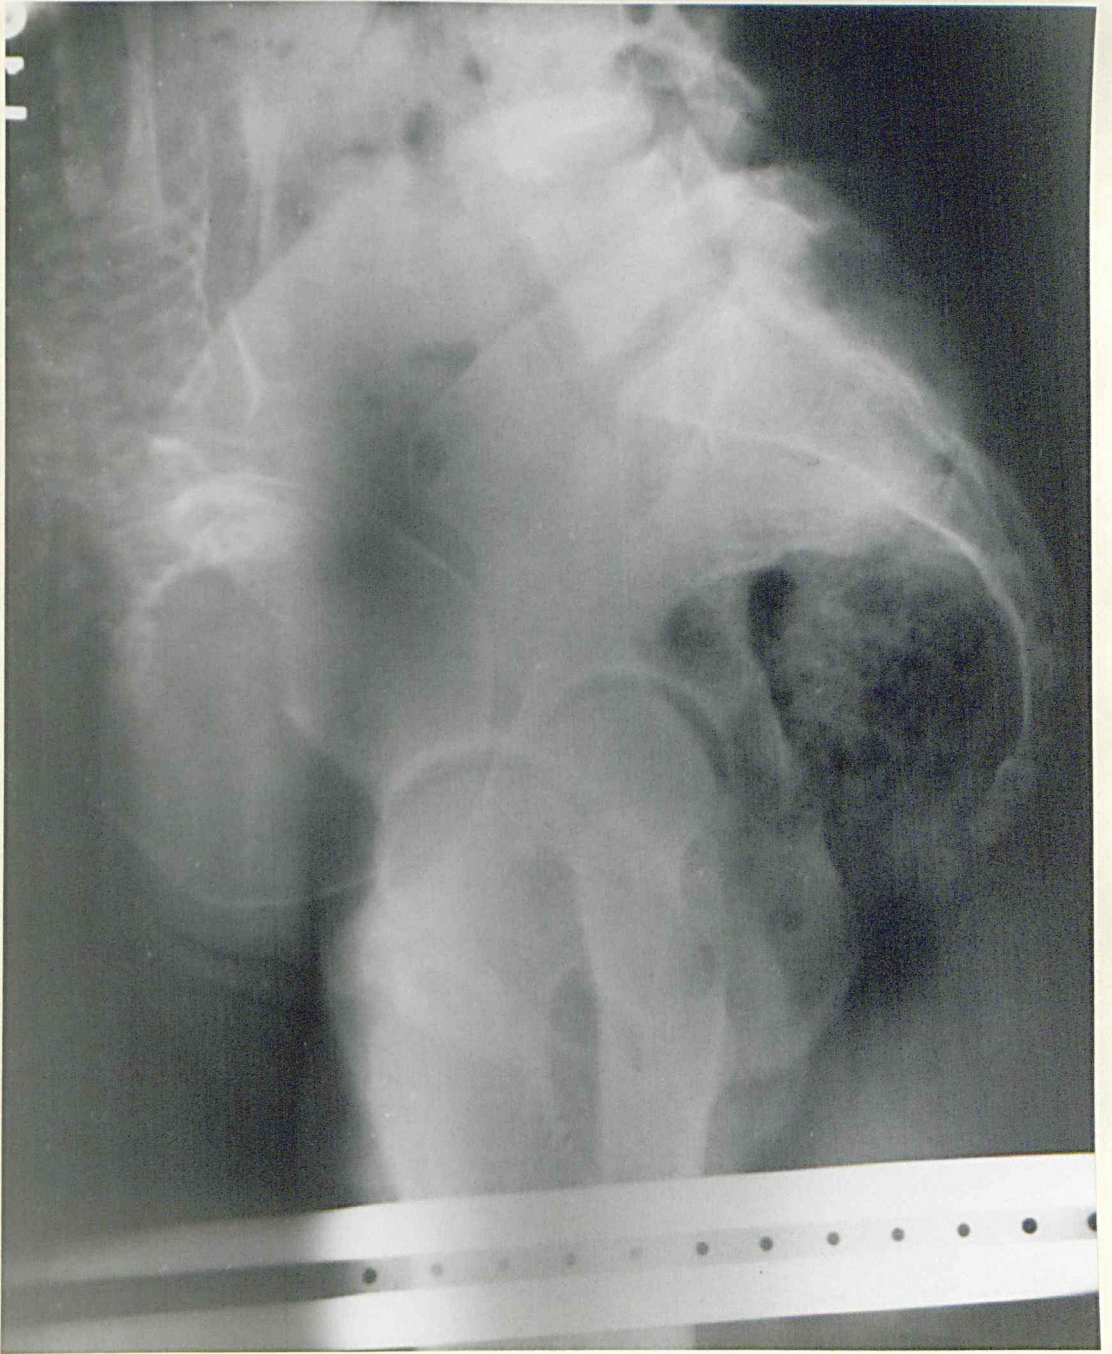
Erect lateral radiograph of the pelvis in a case of posterior placenta praevia. (The same case as Figure 67). The head is displaced forwards from the promontory and there is marked thickening of the posterior "band-like" shadow.
